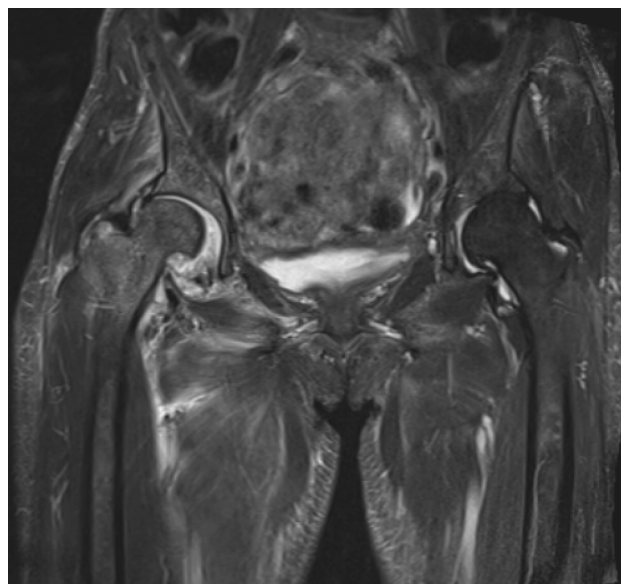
(A) A chest X-ray imaging showed slight deformation of the right femoral bone head and bone joint fissure narrowing. (B) Magnetic resonance imaging detected T2 prolongation in the right femoral bone head, synovial fluid retention, and bone joint fissure narrowing. These findings were not observed in the previous roentgenological imaging five months ago. The patient was diagnosed with right rapidly destructive coxarthrosis as a side effect of crizotinib.
